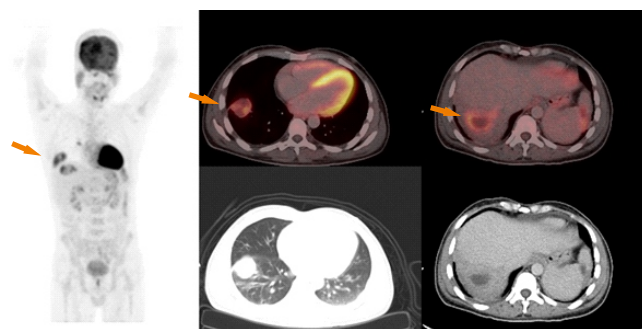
A 47 years old male with end-stage renal disease secondary to membranous glomerulonephropathy. He developed retroperitoneal bleeding with organizing hematoma complicating peritoneal dialysis. He was subsequently switched to hemodialysis. He developed a prolonged fever which did not resolve despite standard diagnostic workup and empirical antibiotic therapy. Fluorine-18-FDG PET/CT was obtained at day 32 following the onset of fever. Images showed multifocal abscesses involving the right lung, liver and the spleen. These abscesses were confirmed to be caused by Enterococcus spp. (arrows)
